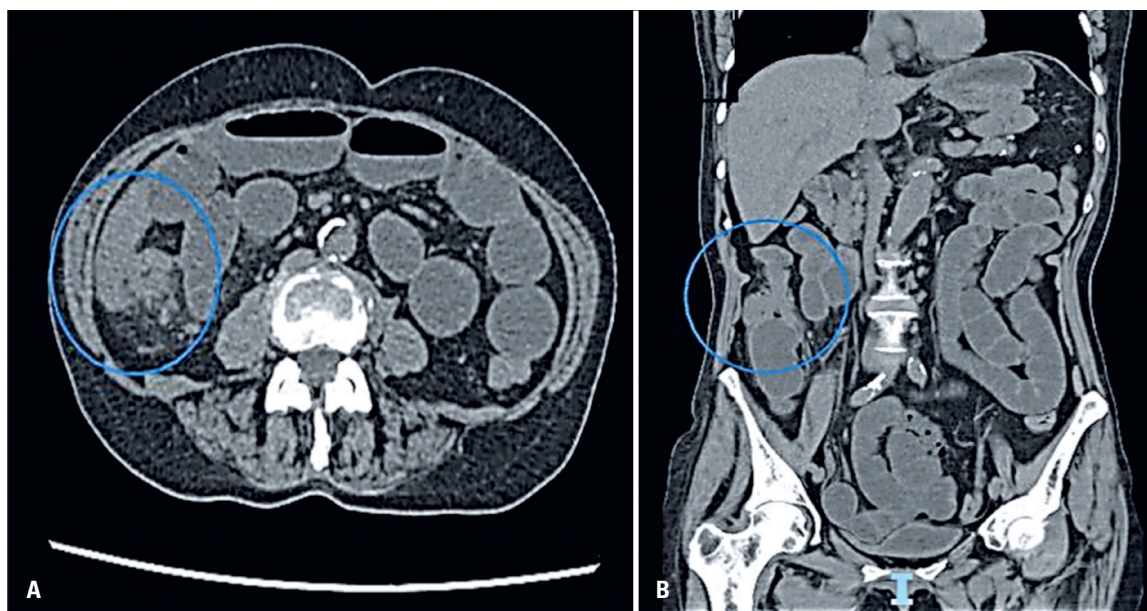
Contrast-enhanced abdominal computed tomography revealing ileocecal involvement. Axial (A) and coronal (B) images demonstrate irregular parietal thickening of the terminal ileum and ileocecal valve (blue circles). These findings were suggestive for an infectious or inflammatory etiology and prompted further investigation with colonoscopy and biopsy
